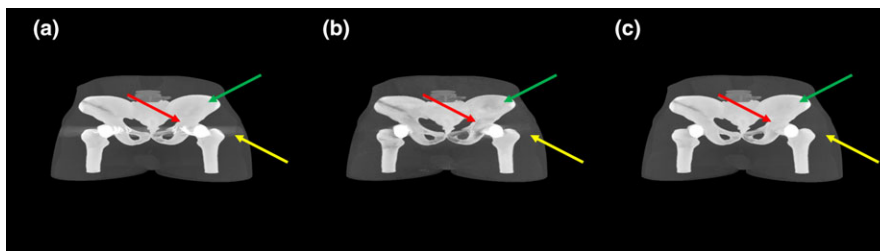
Volume-rendered 3D images in MIP mode of CT data with an (a) ordinary and (b) tilted CT scan, and a (c) result image from the proposed method.
